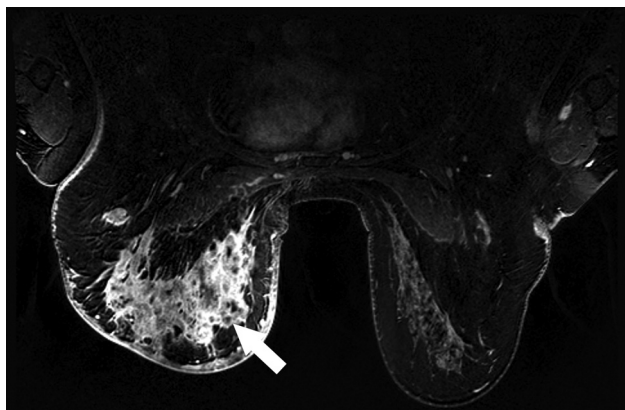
A 35-year-old woman with inflammatory breast cancer presenting for restaging after systemic therapy. T1-weighted fat-suppressed MRI obtained in the transverse plane following administration of a gadolinium chelate demonstrates marked left breast skin thickening and clustered ring enhancement (arrow). Subsequent MRI-guided biopsy revealed granulomatous mastitis.
